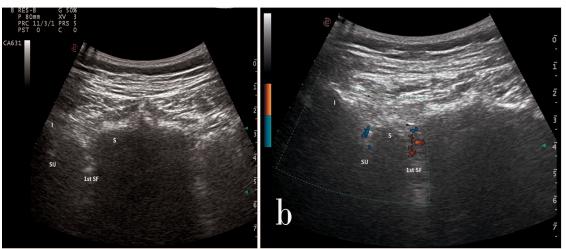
Upper left: Representative image on greyscale, at the level of the first sacral foramen. Upper right: Representative image at the level of the first sacral foramen. Increase of the abnormal vascularization at the level of the left SIJ, due to the presence of color Doppler signal. Visible vascularization at the level of first sacral foramen. Lower image: Representative image at the level of the first sacral foramen. Increase of the abnormal vascularization at the level of the left SIJ, due to the presence of color Doppler signal. The resistance index measured at this level shows a value of 0.55, indicating the presence of sacroiliitis due to the phenomenon of neo-angiogenesis. Visible vascularization at the level of first sacral foramen. S: sacral; I: iliac; SIJ: sacroiliac joint; SF: first sacral foramen.
